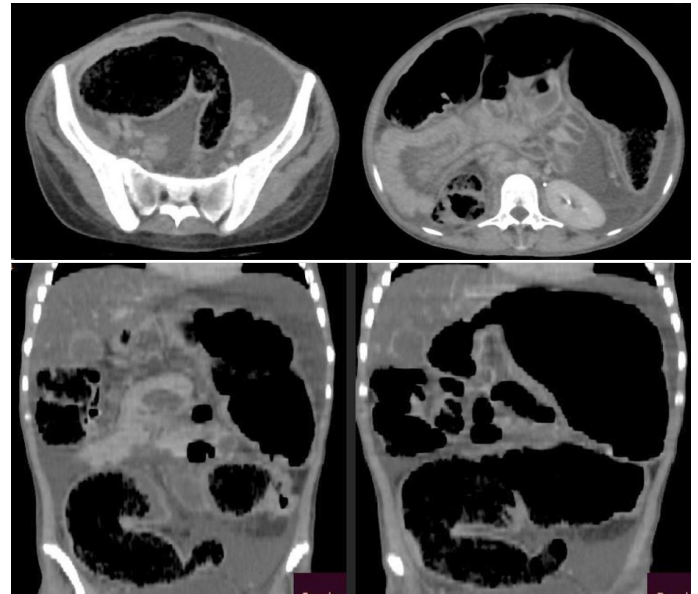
Axial and coronal section of abdominopelvic CT-scan with contrast shows significant colonic dilatation above transition zone and collapsed rectum below as indicated by black arrow.
